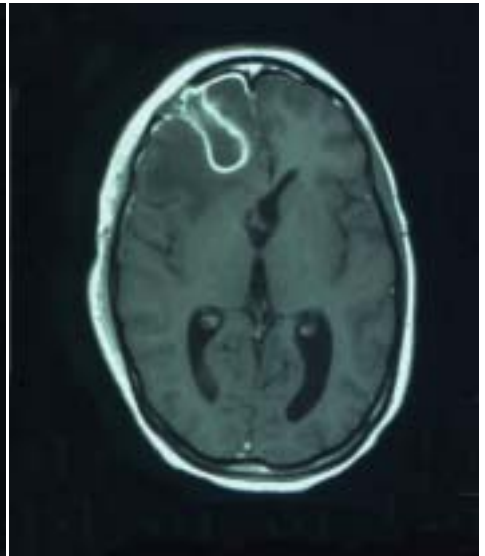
This Gadolinium enhanced MRI scan taken 4 weeks later shows involution of the abscess cavity. Intravenous ceftriaxone and metronidazole were continued for a further 3 weeks followed by 3 weeks of oral Augmentin. A repeat scan 1 month later showed further involution of the cavity.
